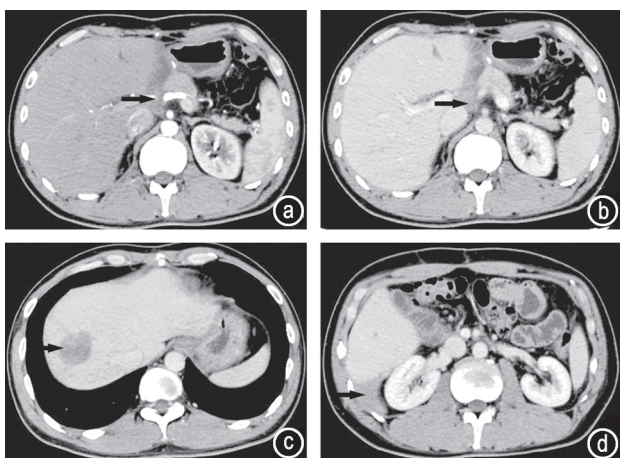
CT findings after therapy for 8 months. (a–b) Abdominal CT showed no recurrence in the uncinate lobe of the pancreas after resection on contrast CT; (c–d) CT showed two low-density masses in the right lobe of the liver
